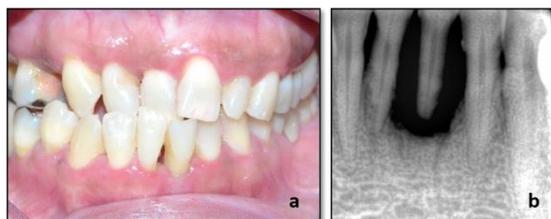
(a) Anterior crossbite between teeth 13 - 43, 12 - 42, 11 - 41 & 31; (b) Radiographic bone loss up to the apex
